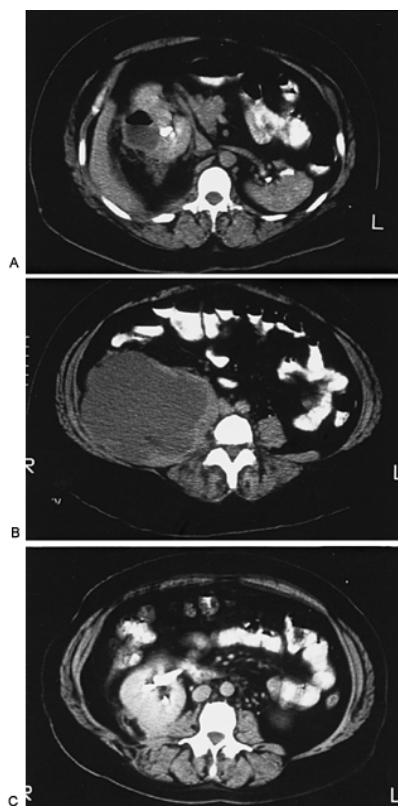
A: An obstructing upper-pole stone is present on this computed tomography scan. B: A large, retroperitoneal abscess caused by the obstruction and resulting infection. C: Three months after percutaneous stone removal and drainage of the abscess cavity, renal function has returned to normal and the abscess cavity has completely resolved.
